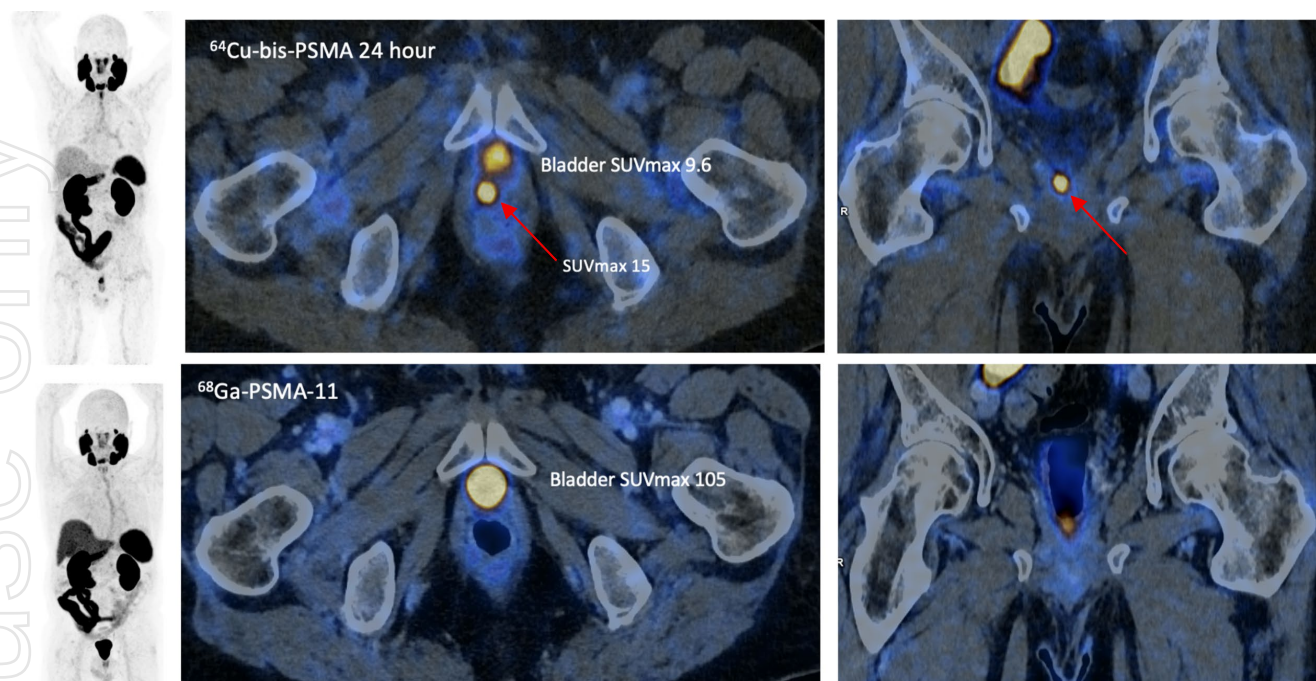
The 24-hour ^{64}Cu -bisPSMA positive lesion in the prostate fossa (SUVmax 15) was confirmed as true positive with PSA response to fossa radiotherapy (top images, red arrow). ^{68}Ga -PSMA-11 scan was reported as negative by all readers (bottom images). Images demonstrate the improved tumour-to-background activity in the prostate fossa with the bladder SUVmax significantly lower on ^{64}Cu -SAR-bisPSMA images compared to ^{68}Ga -PSMA-11.
